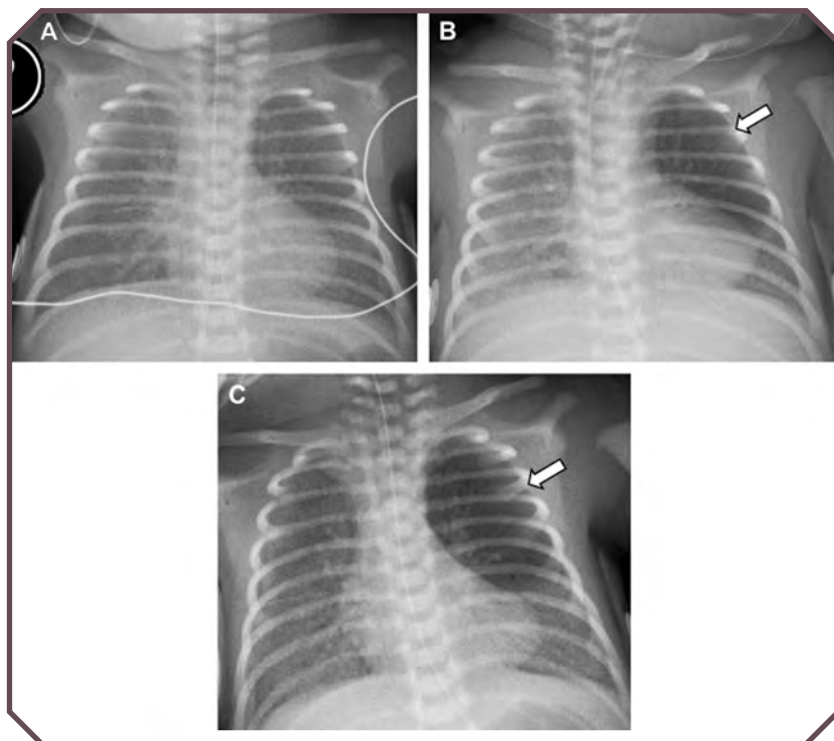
Congenital lobar emphysema in a female neonate with progressively worsening respiratory distress. A. Initial frontal chest radiograph obtained at birth is unremarkable. B. Frontal chest radiograph obtained 4 hours after birth demonstrates interval development of hyperlucency (arrow) in the left upper lobe. C. Frontal chest radiograph obtained 7 hours after birth shows increased hyperlucency (arrow) of the left upper lobe. From Lee EY, Dorkin H, Vargas SO. Congenital pulmonary malformations in pediatric patients: review and update on etiology, classification, and imaging findings. *Radiol Clin North Am.* 2011;49(5):921–948. Copyright 2011, with permission from Elsevier.
